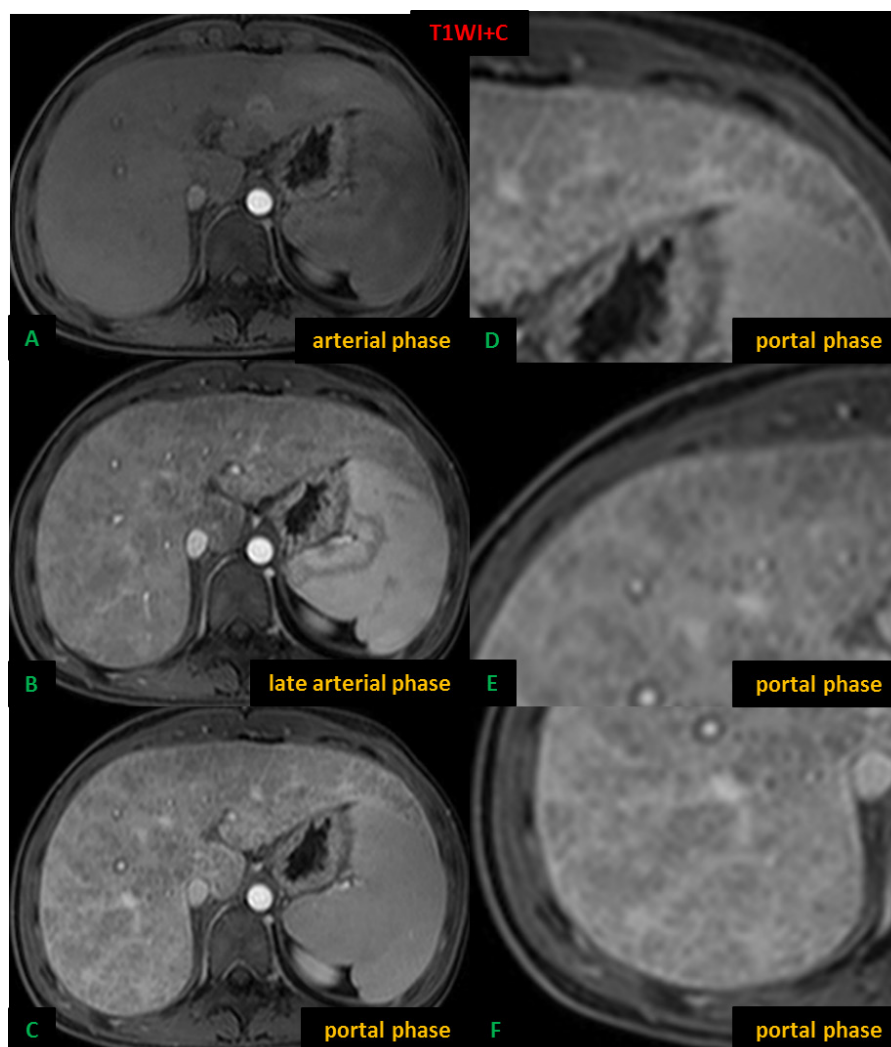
Dynamic MRI of the aforementioned case of bridging fibrosis. A reticular pattern of linear enhancement discerns in late arterial phase and becomes more conspicuous on portal venous phase (A,B,C). Enlarged images of portal venous phase (D,F,E) better depict the fine linear enhancement of fibrous septa surrounding isointense regenerative nodules.
